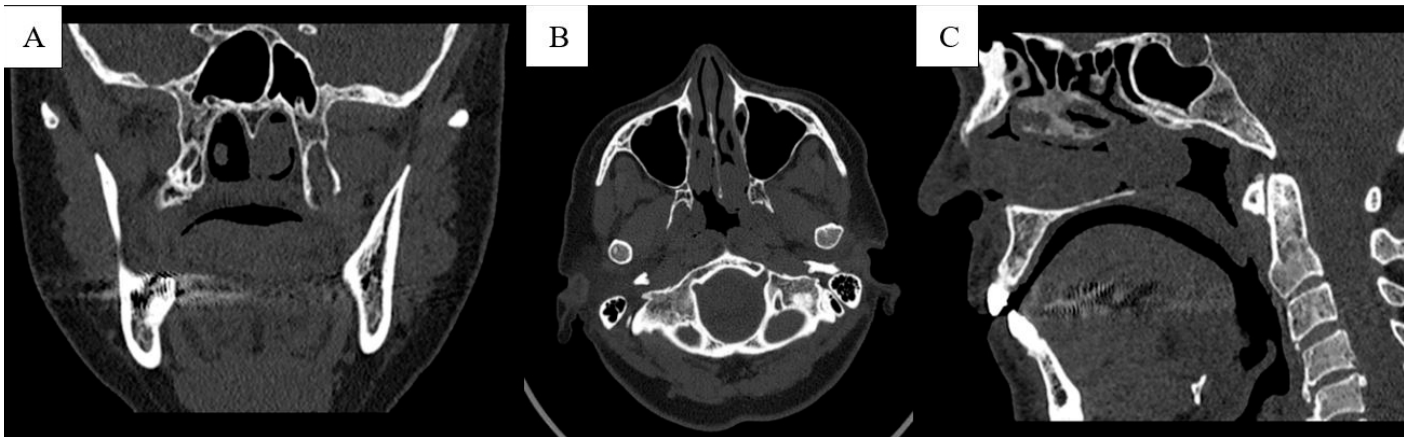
Computed tomography showing a polypoid lesion arising from the posterior portion of the left inferior turbinate expanding towards the left choana with slight contrast enhancement. Coronal (A), axial (B), and sagittal (C) planes.
